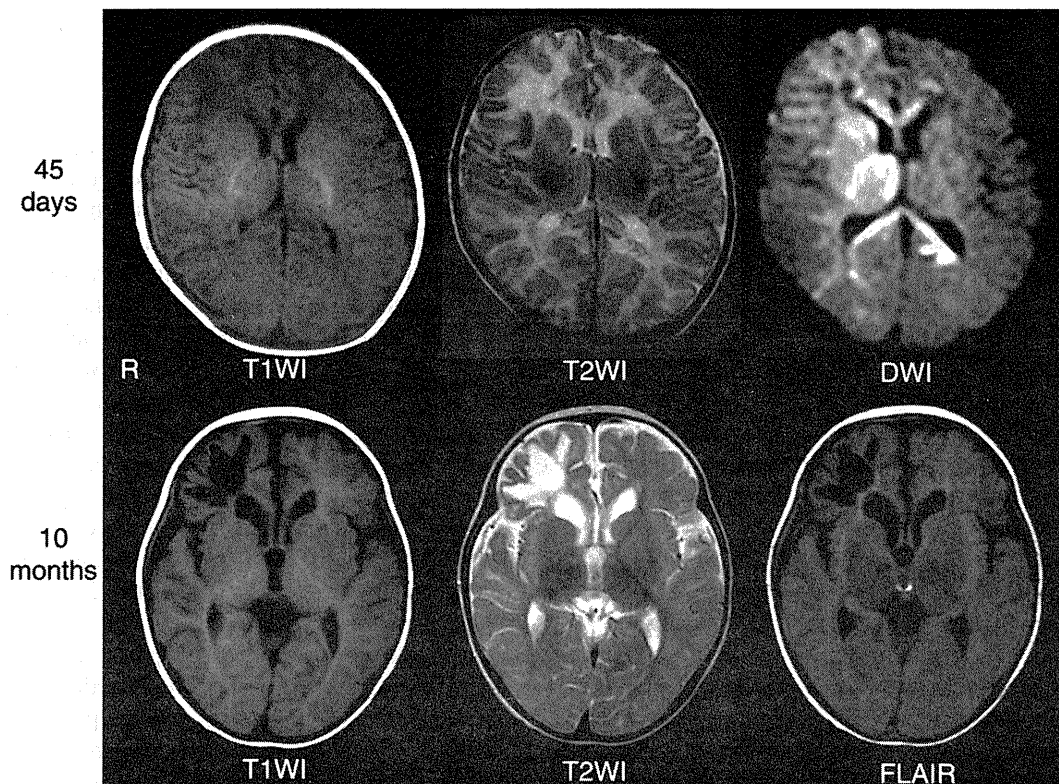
MRI findings of Patient 1. Top: MRI at 45 days of age. Diffusion-weighted images revealed reduced diffusion predominantly in the subcortical white matter in the right frontal area. Reduced diffusion was also observed in the basal ganglia, thalamus, corpus callosum, and posterior limb of the internal capsule. In T2-weighted images, mildly increased signal intensities were seen in the subcortical white matter in the right frontal area. Bottom: MRI at 10 months of age. Marked encephalomalacia was seen in the right frontal lobe. The frontal horn of the right lateral ventricle was mildly dilated. T1WI, T1-weighted images; T2WI, T2-weighted images; FLAIR, fluid-attenuated inversion-recovery images; DWI, diffusion-weighted images; R, right.
